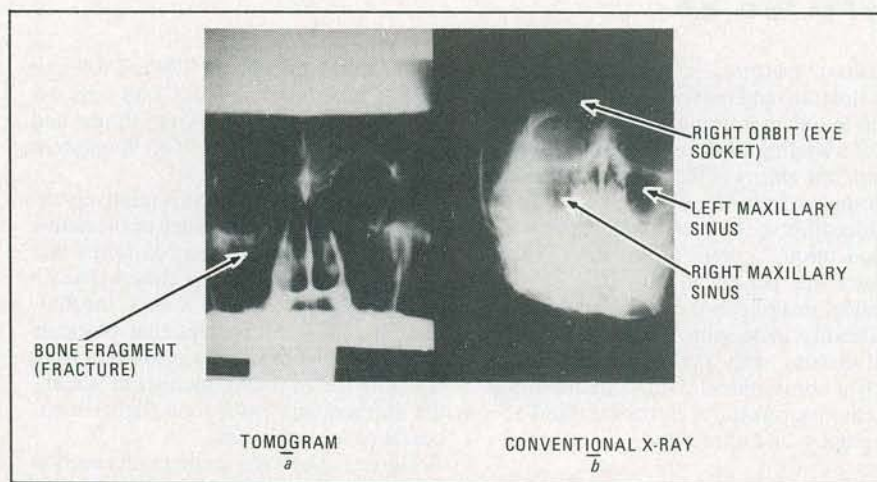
A BONE FRAGMENT that shows up in the tomogram in a, does not show up in the conventional X-ray shown in b.
